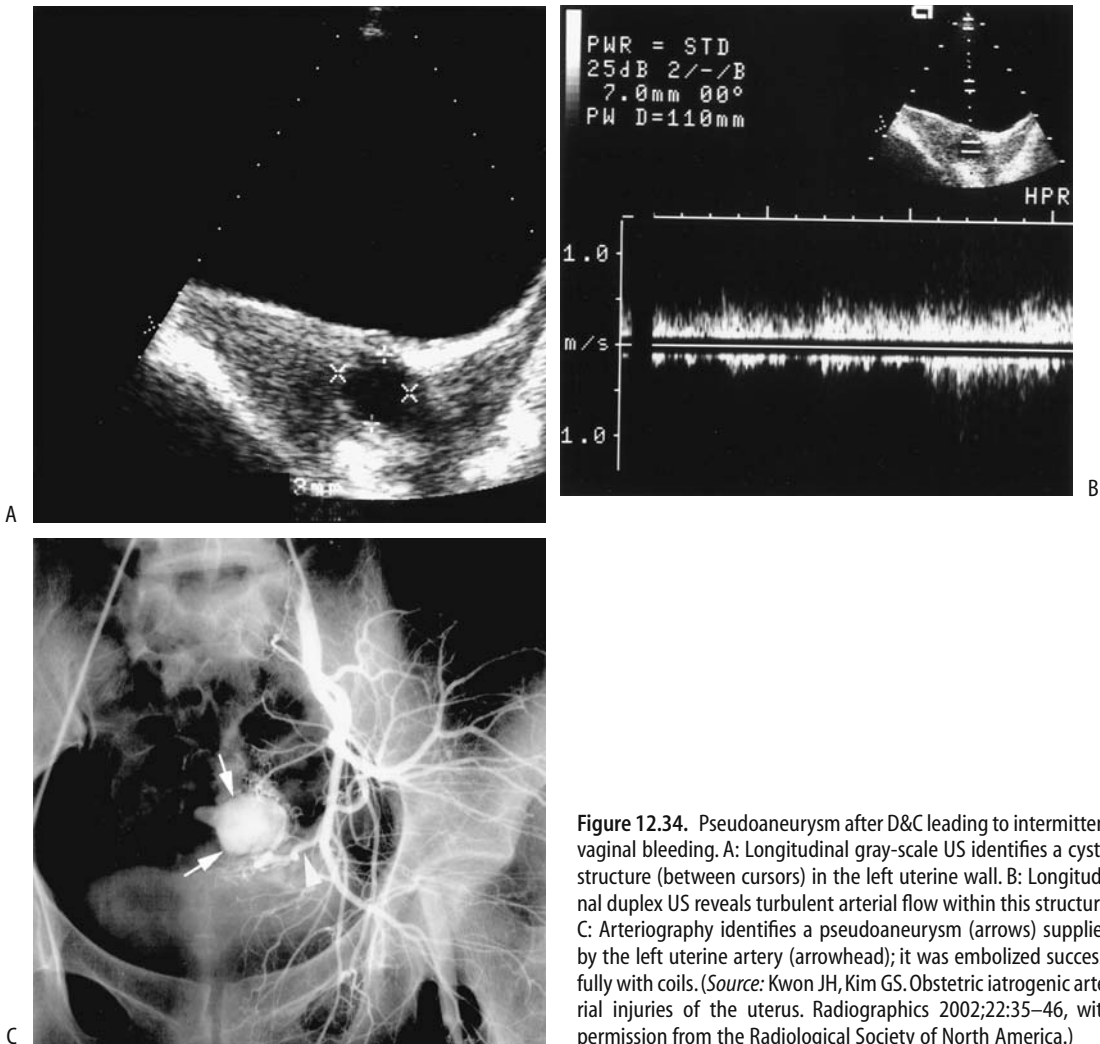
Pseudoaneurysm after D&C leading to intermittent vaginal bleeding. A: Longitudinal gray-scale US identifies a cystic structure (between cursors) in the left uterine wall. B: Longitudinal duplex US reveals turbulent arterial flow within this structure. C: Arteriography identifies a pseudoaneurysm (arrows) supplied by the left uterine artery (arrowhead); it was embolized successfully with coils. (Source: Kwon JH, Kim GS. Obstetric iatrogenic arterial injuries of the uterus. *Radiographics* 2002;22:35–46, with permission from the Radiological Society of North America.)
